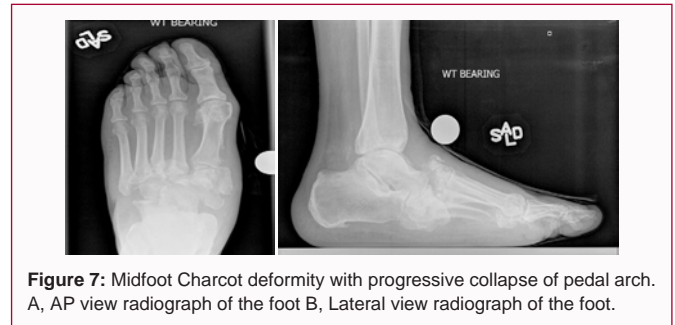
Midfoot Charcot deformity with progressive collapse of pedal arch. A, AP view radiograph of the foot B, Lateral view radiograph of the foot.
